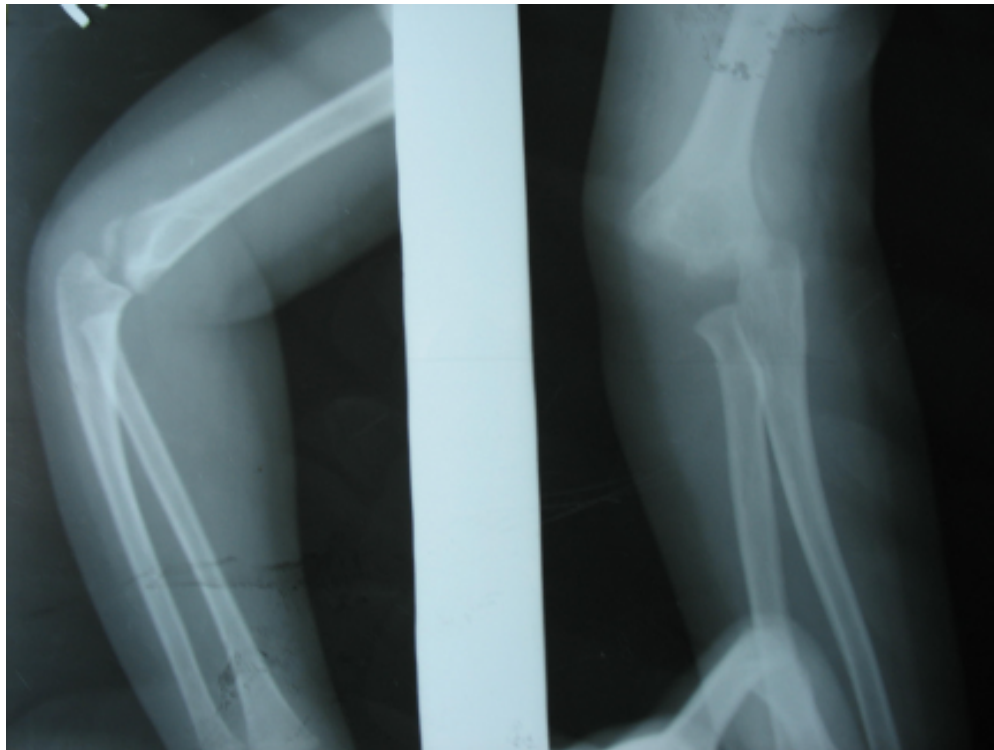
X-ray showing fracture dislocation of elbow
